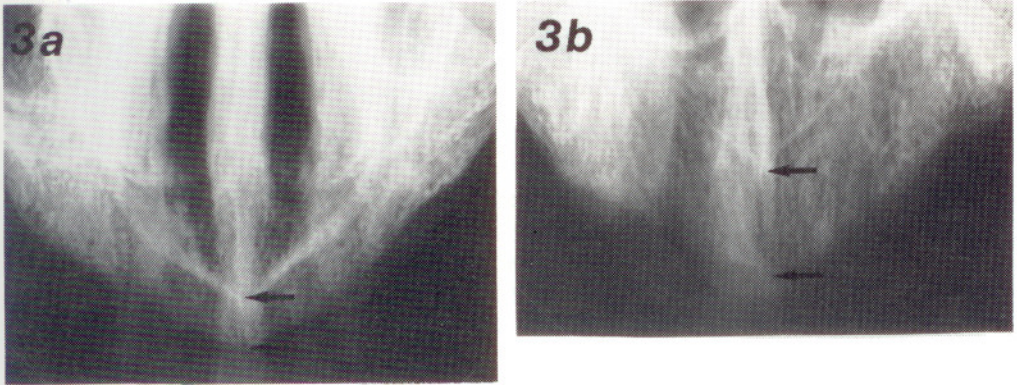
"Antemortem" radiograph. Fig. 3b "Postmortem" radiograph. Five errors were made by the observers in this case. The projections are very different. The "ante- and the postmortem" radiographs seem to have been mixed up, but a "gain" in alveolar bone (arrowed) as seen on the "postmortem" radiograph was an artifact in this case.
